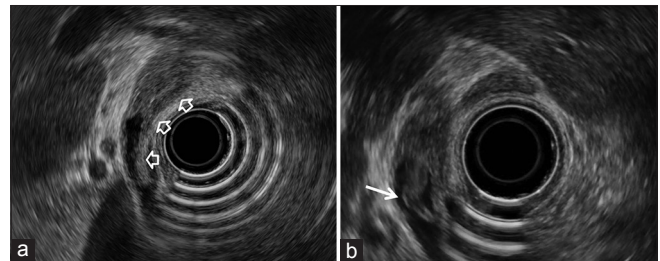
Endoscopic ultrasound (EUS) images showing (a) mixed echogenic material (open arrows) with duct dilatation and (b) moving spontaneously a few seconds later (white arrow) at common bile duct
